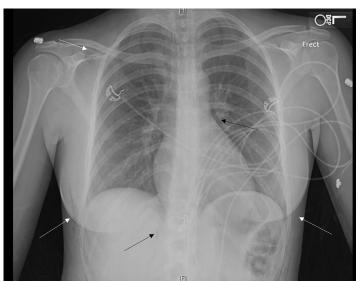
Chest radiograph demonstrating pneumoperitoneum (lower black arrow), subcutaneous emphysema (white arrows), and pneumopericardium (upper black arrow).
